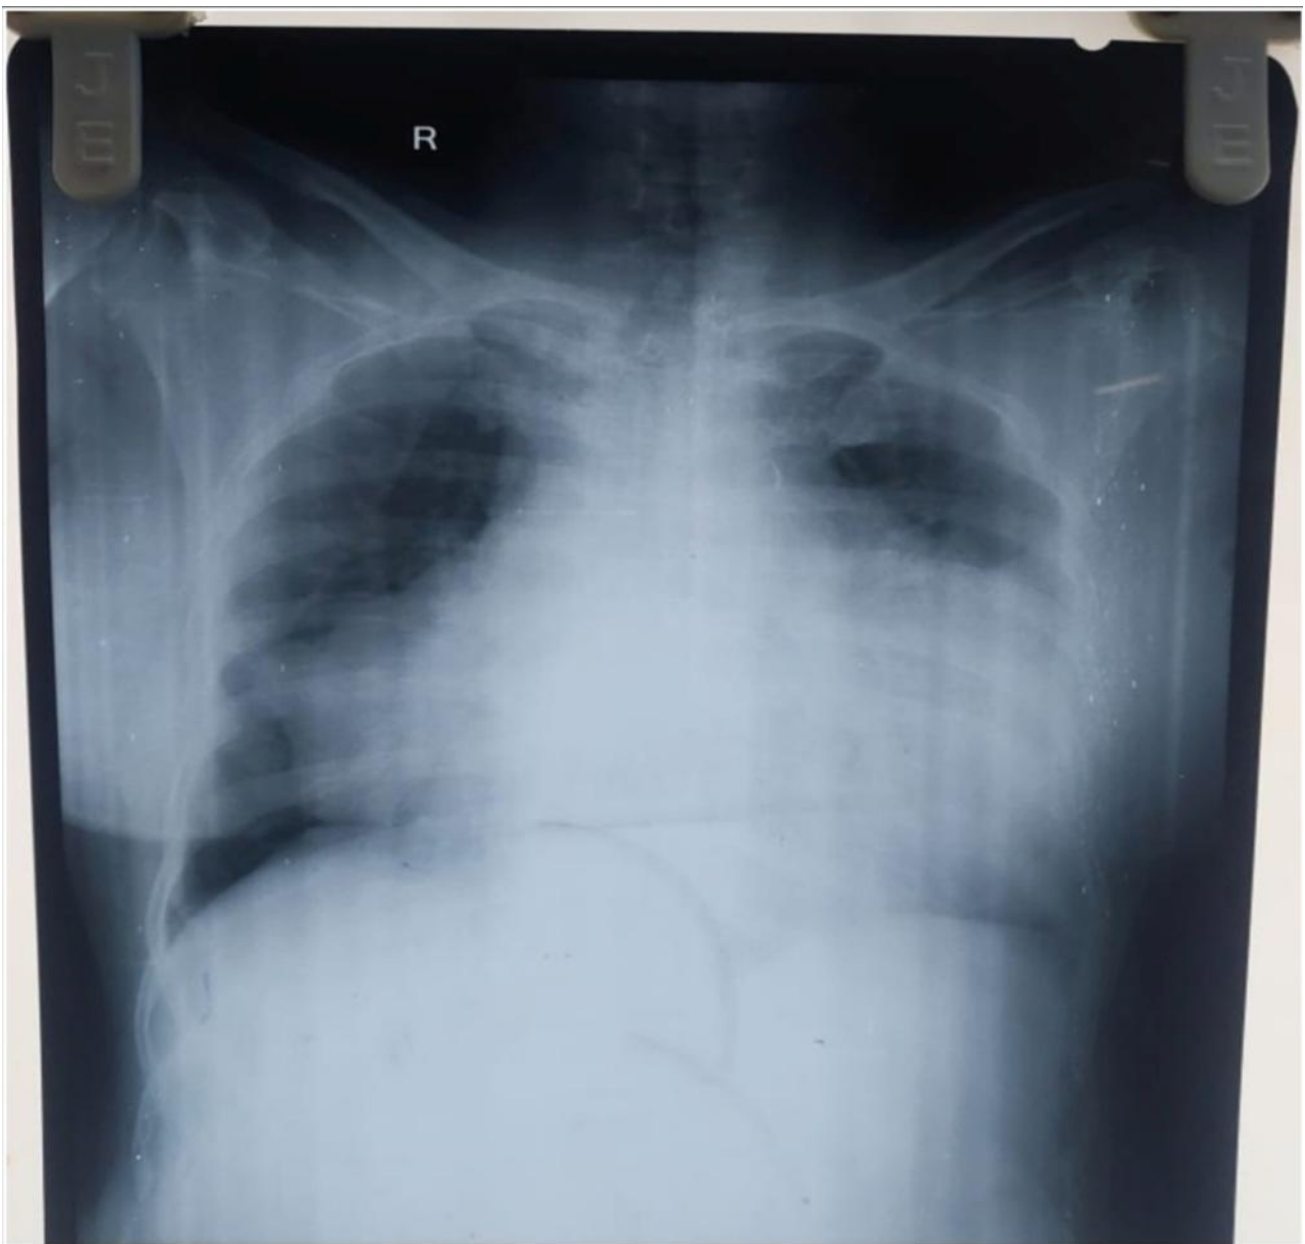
Chest X-ray PA view showing left sided pleural effusion with cardiothoracic ratio more than 0.5 (cardiomegaly).
